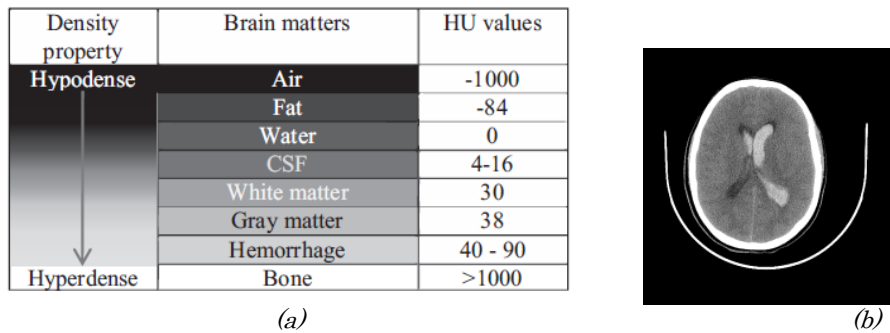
(a) Intensity varies with density in CT image (b) CT image
